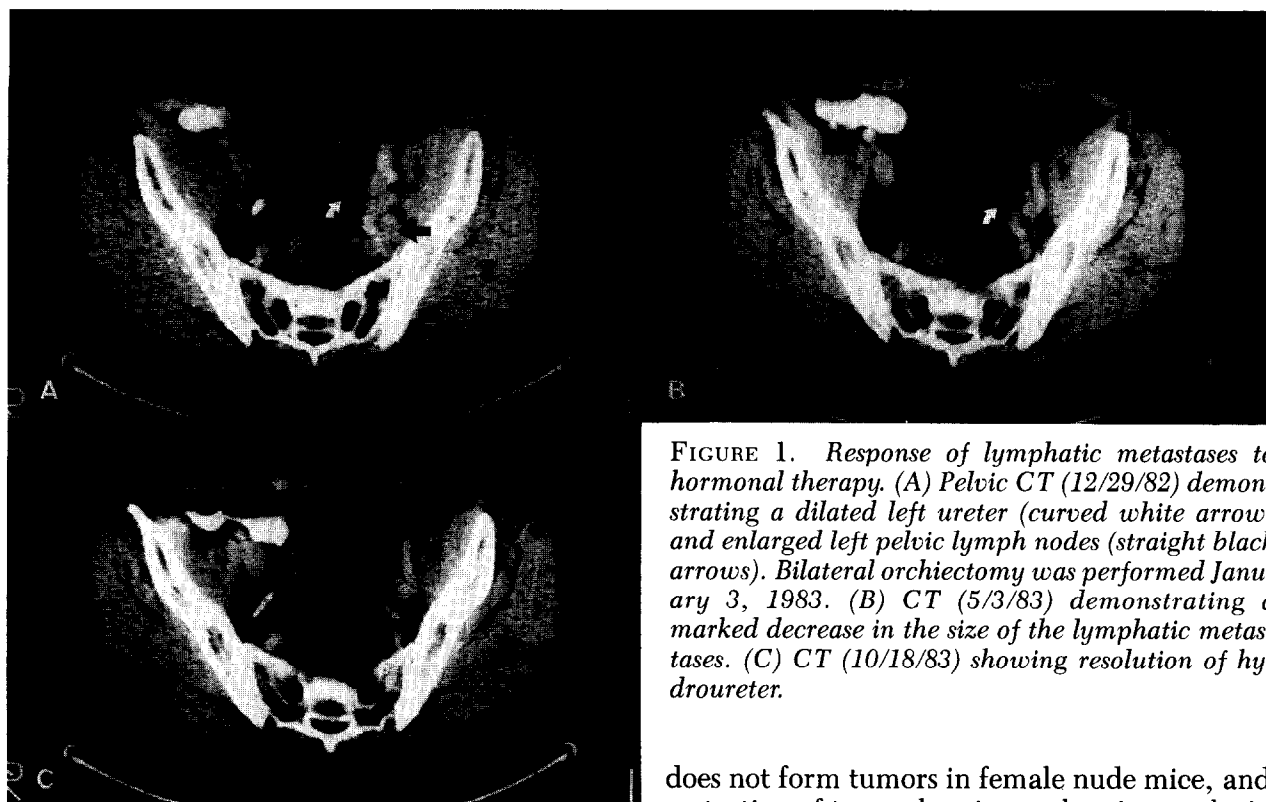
Response of lymphatic metastases to hormonal therapy. (A) Pelvic CT (12/29/82) demonstrating a dilated left ureter (curved white arrow) and enlarged left pelvic lymph nodes (straight black arrows). Bilateral orchiectomy was performed January 3, 1983. (B) CT (5/3/83) demonstrating a marked decrease in the size of the lymphatic metastases. (C) CT (10/18/83) showing resolution of hydronephrosis.
